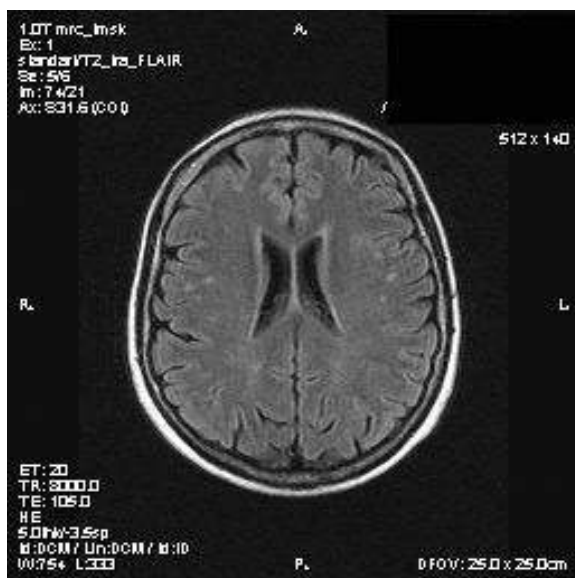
A snapshot of the brain in the axial projection in the FLAIR mode in the white matter of the frontal and parietal lobes is determined by small foci of increased signal on T2 and FLAIR, without signs of perifocal edema, of a dystrophic nature (photo by Matveeva, 2015).
